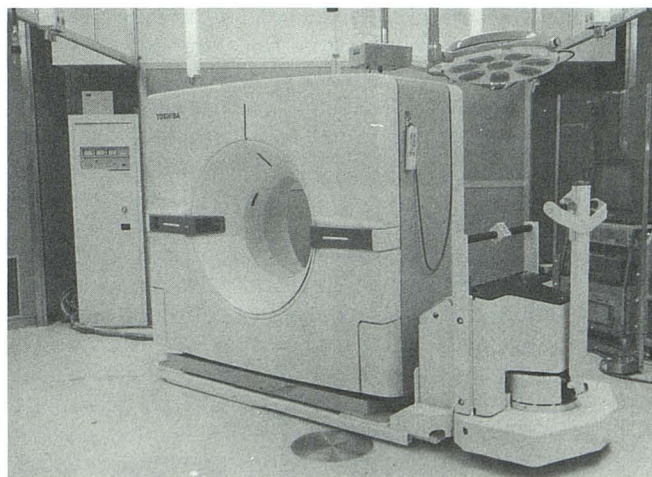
Photograph of mobile CT gantry on gantry carrier. The scanner can be moved in any direction by operating the carrier.
